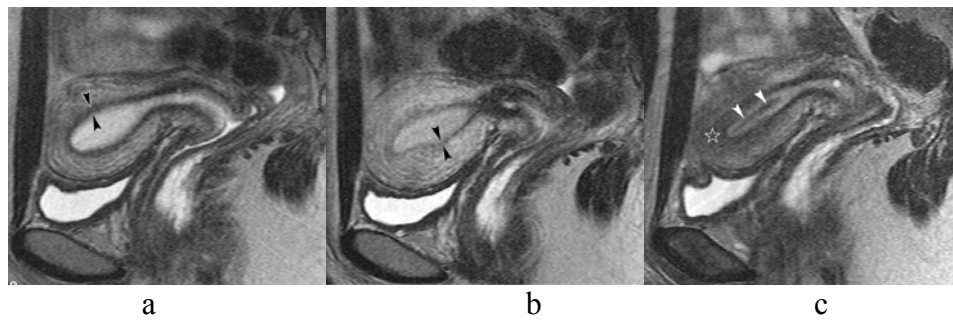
Uterine changes during the menstrual cycle in a 31-year-old woman. (a) Sagittal T2-weighted image obtained during the periovalutary phase shows the anatomy of the three zones: endometrium, junctional zone (arrowheads), and outer myometrium. (b) Sagittal T2-weighted image obtained during the midsecretory phase shows increased thickness of the endometrium and myometrium. The signal intensity of the outer myometrium is increased. The thickness of the junction zone (arrowheads) is significantly decreased. (c) Sagittal T2-weighted image obtained during the menstrual phase shows that the uterine corpus appears smaller than during the periovalutary and midsecretory phases. The zonal anatomy of the myometrium is ill defined and irregularly thick (*). The low-signal-intensity band in the middle of the endometrium (arrowheads) represents menstrual blood (*Quoted from Kido et al., 2003*).
